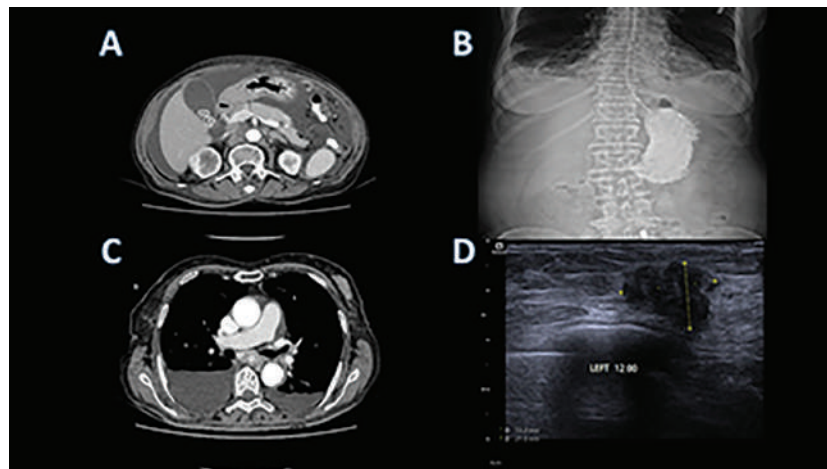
Radiological findings. (A) Contrast-enhanced abdominal CT demonstrating diffuse gastric wall thickening and a mass lesion in the antrum causing luminal narrowing. (B) Upper gastrointestinal contrast study showing marked narrowing in the antrum consistent with gastric outlet obstruction. (C) Thoracic CT demonstrating an irregular, solid mass lesion in the left breast. (D) Breast ultrasonography showing a hypoechoic, irregularly bordered mass lesion measuring approximately 21×13 mm at the 12 o'clock position of the left breast.
